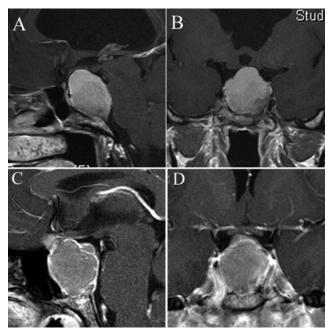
Imaging examples demonstrating the potential difficulty in differentiating atypical CPs and RCCs. A and B: Sagittal and coronal Gd-enhanced MR images obtained in a patient with a recurrent RCC, demonstrating suprasellar, clival, and retrosellar extension. C and D: Sagittal and coronal Gd-enhanced MR images obtained in a patient with a cystic CP, also demonstrating suprasellar and infrasellar extension.
